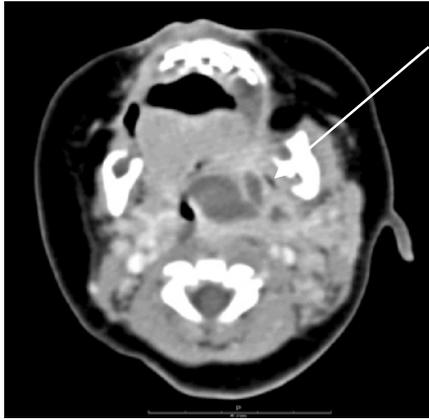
Cervical axial CT scan shows a low attenuation density with peripheral rim enhancement on the left peritonsillar area.
